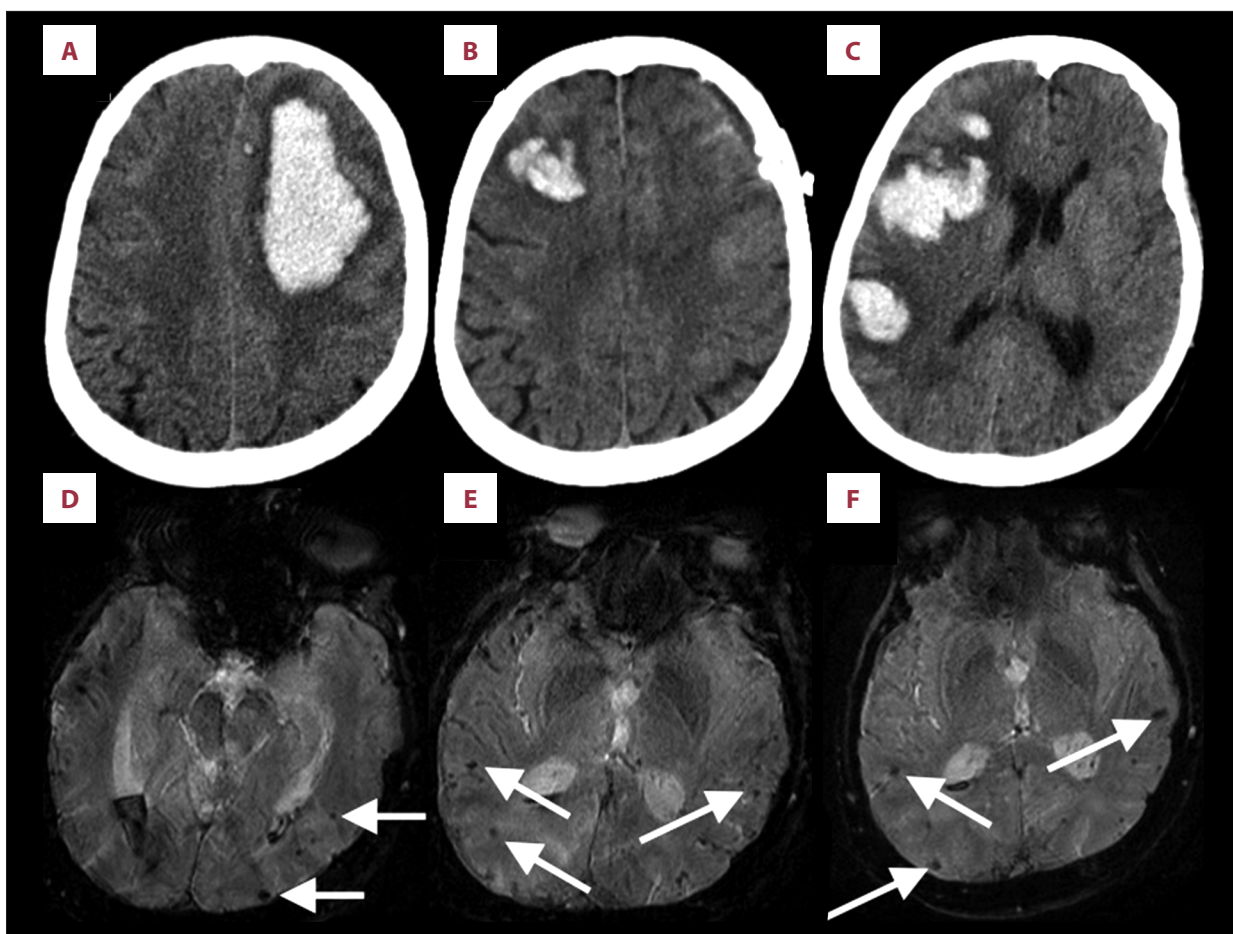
(A–C) CT head images. CT head scan on admission (A), one week later (B), and 25 days after admission (C). (D–F) Susceptibility weighted MR imaging, limited by motion artifact, demonstrates multiple strictly lobar microbleeds (white arrows) suggestive of cerebral amyloid angiopathy.
